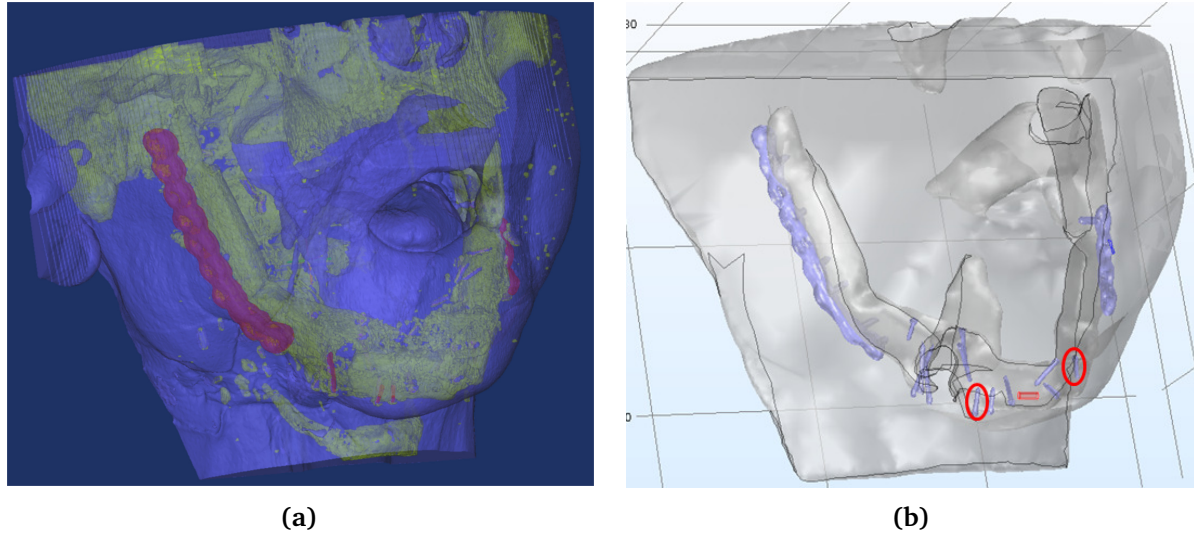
Slices from a computer tomography (CT) scan of a patient with a critical-size defect of the mandible. Reproduced from [36] with permission from Springer Nature.
